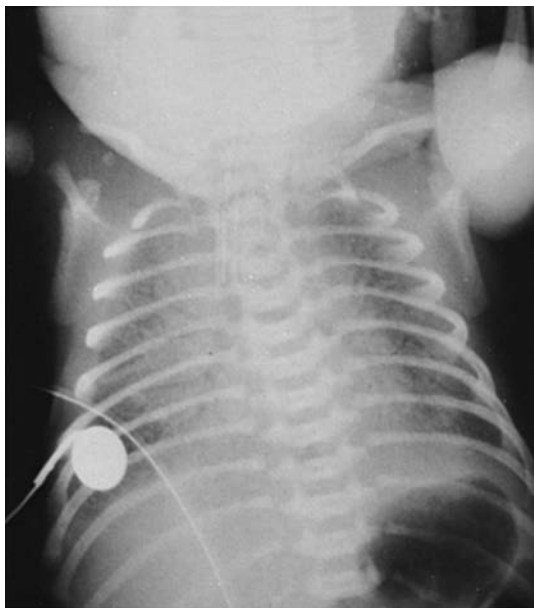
Chest x-ray film of a preterm infant (27 weeks' gestation) with respiratory distress syndrome. Note characteristic infiltrate pattern with air bronchograms.
